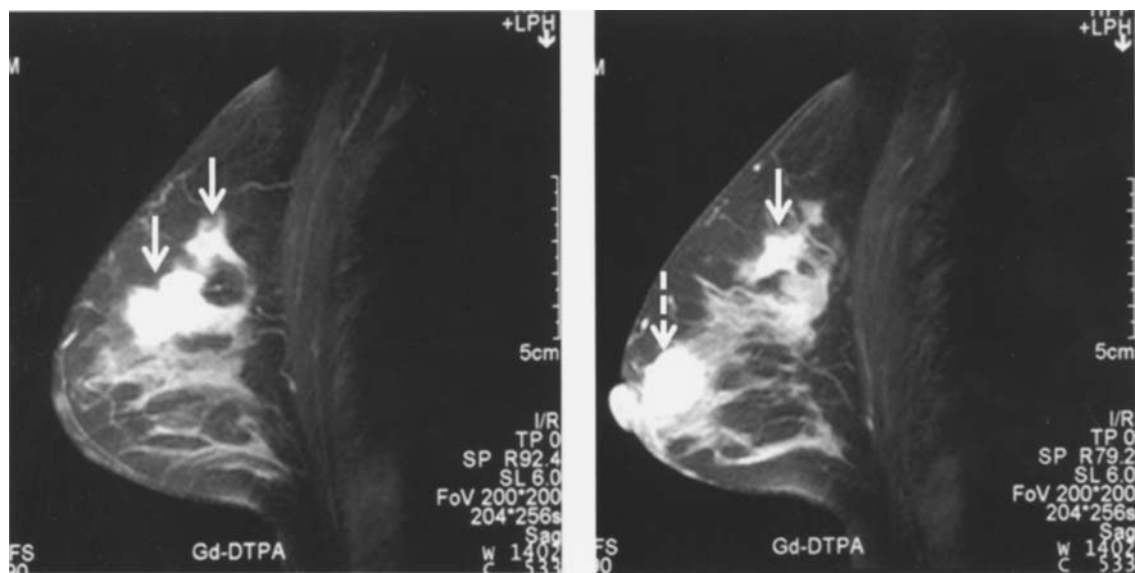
Contrast-enhanced MRI of the patient's breast. There were several enhanced masses in the right upper outer (solid arrow) and central (dotted arrow) quadrants.
